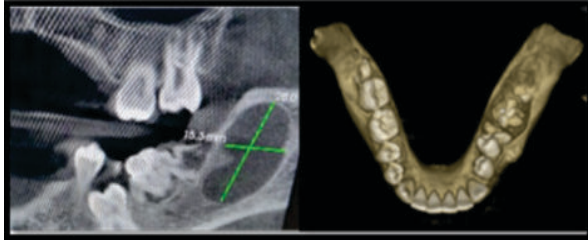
CBCT showing cyst and presence of odontome
